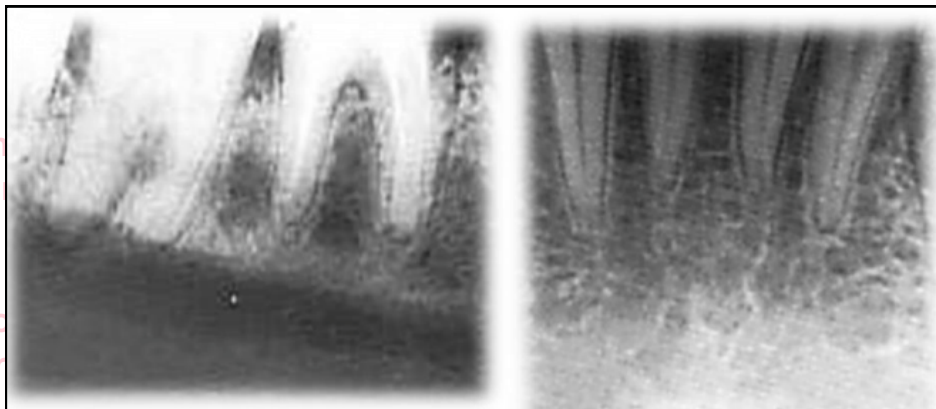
Bitewing – Mandibular Bone Margin Cut Off
